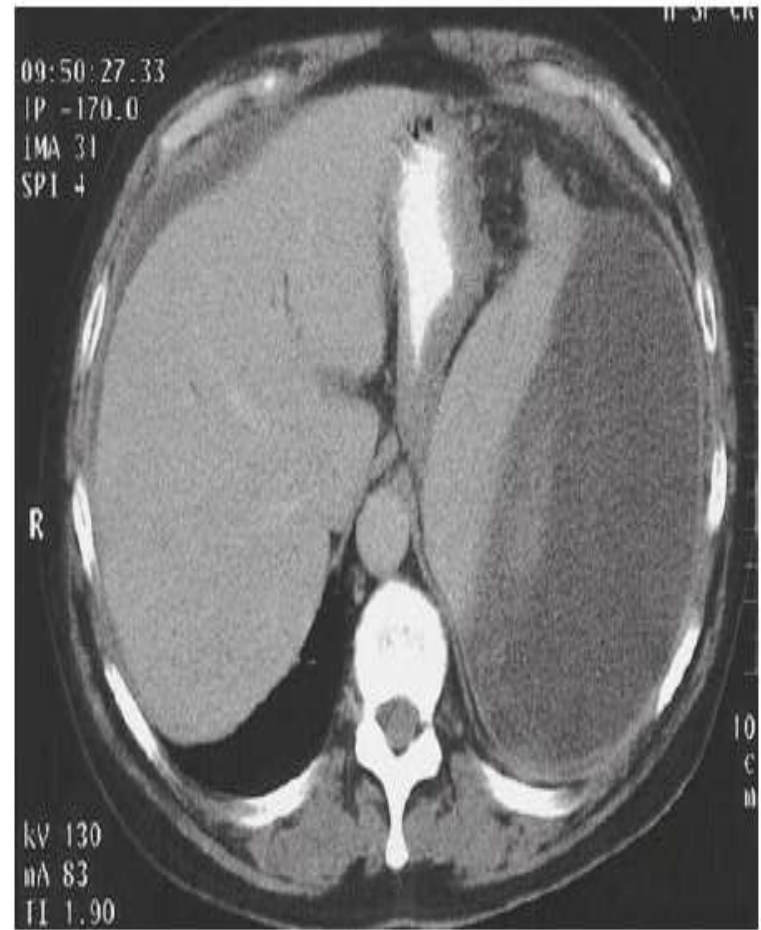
Computed tomographic scan showing a large pseudocyst involving the spleen. There is displacement of the stomach medially, and a trace of ascitic fluid is present above the liver.
